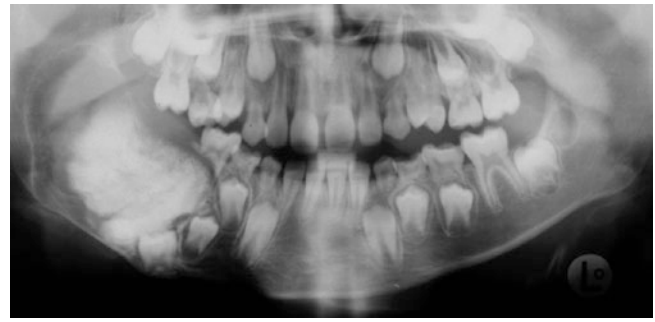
Panoramic radiograph showing radiodense mass in connection with a tooth germ, a picture typical for complex odontoma
